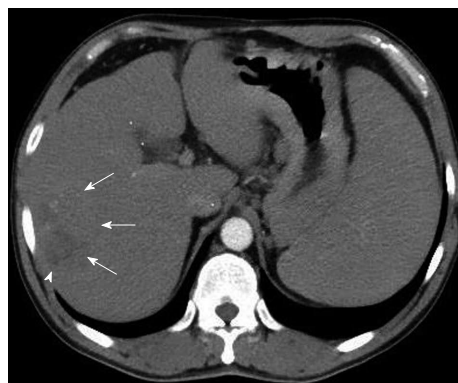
Contrast-enhanced axial computed tomography during the arterial phase showed one ill-defined mass with heterogeneous enhancement (arrows) and central necrosis (arrowhead) at segment 7.
